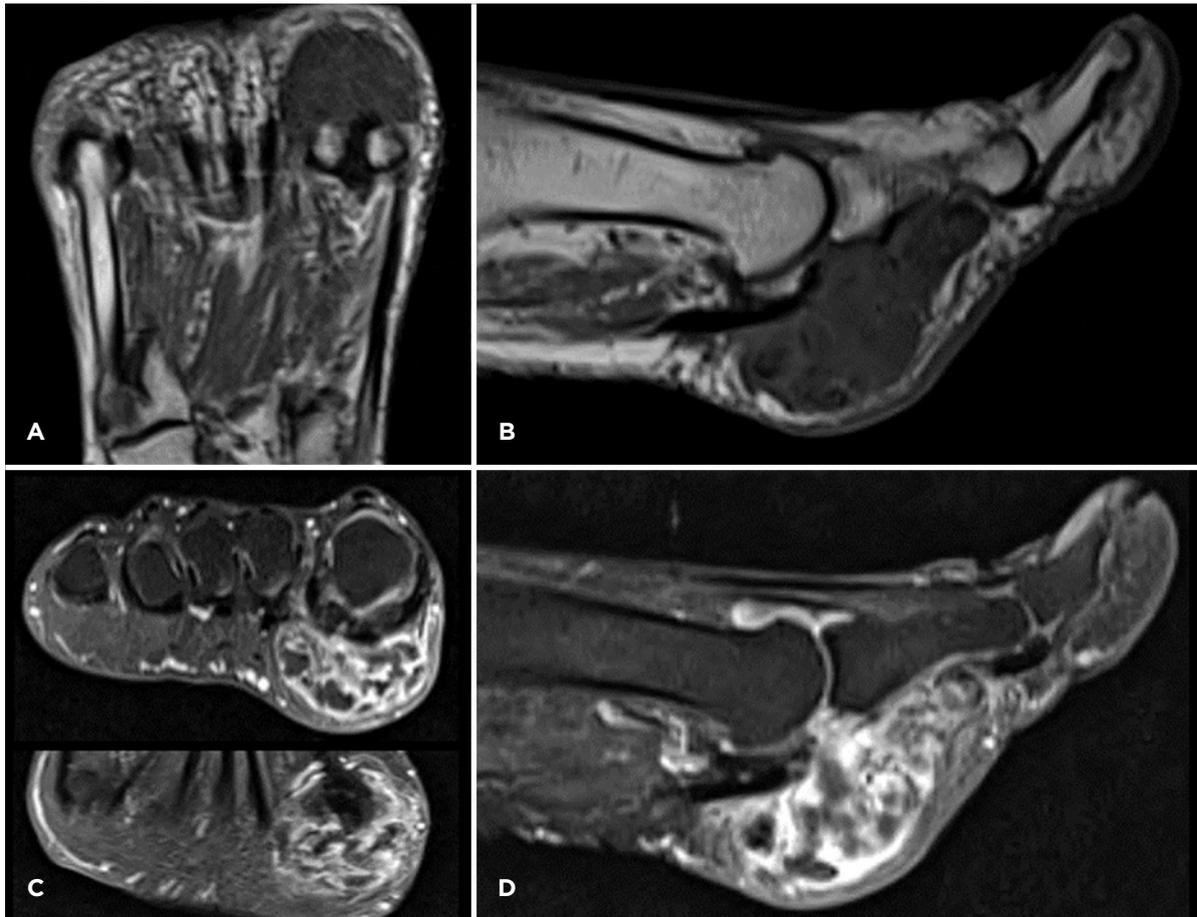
(A) T1-weighted axial MRI image showing a mass with uniformly low signal. (B) T1-weighted sagittal MRI image showing a mass with uniformly low signal. (C) Fat-saturation with contrast axial MRI image showing increased signal with calcification and rim enhancement. (D) Fat-saturation with contrast sagittal MRI image showing increased signal with calcification and rim enhancement.
